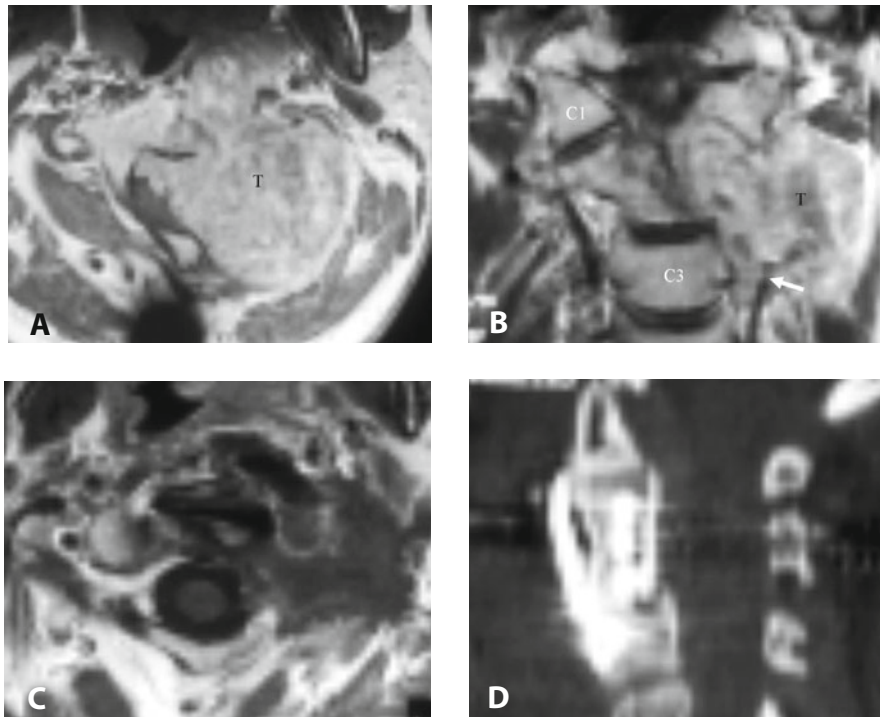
Chordoma. A–D. Preoperative workup. On figure C, arrows indicate the posterior shift of the dura mater. E–H. Postoperative CT scan after complete tumor resection. I–J. Postoperative fixation and bone grafting at 1 year. C: clivus. C1: atlas. C2: axis. T: tumor.
